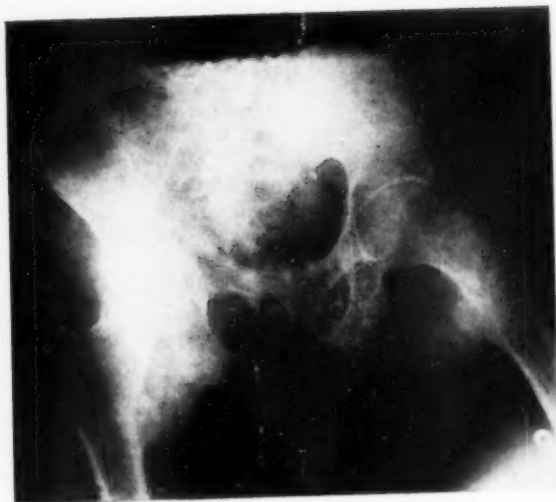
Case No. 679. Roentgenogram of the pelvis in AP projection revealing comminuted cervico-trochanteric fracture of the left femur.
